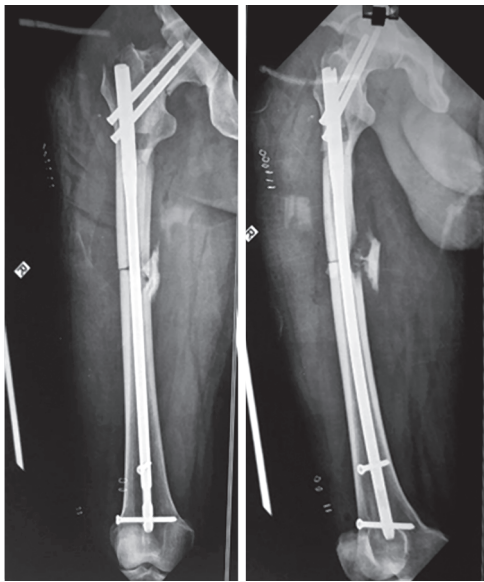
Immediate postoperative X-ray following cephalomedullary nailing
